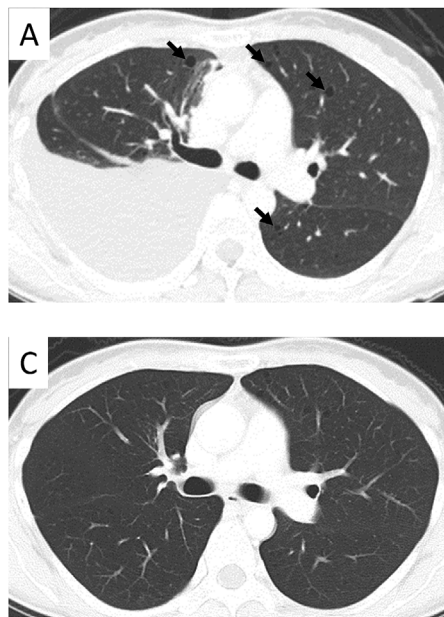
Computed tomography (CT) scans (1.25-mm slice) on admission (A, B) and after 2 months of sirolimus treatment (C, D). A: Chest CT scan revealing moderate accumulation of the right pleural effusion and multiple thin-walled cysts (arrows) in both lung fields. B: Enhanced abdominal CT scan demonstrating ascites and a solid tumor (arrowheads) in the right pelvis. C: Chest CT scan revealing that the multiple small cysts in both lungs are stable and pleural effusion retention is decreased. D: Enhanced abdominal CT scan showing that the quantity of ascites fluid and size of the tumor lesion are smaller.
